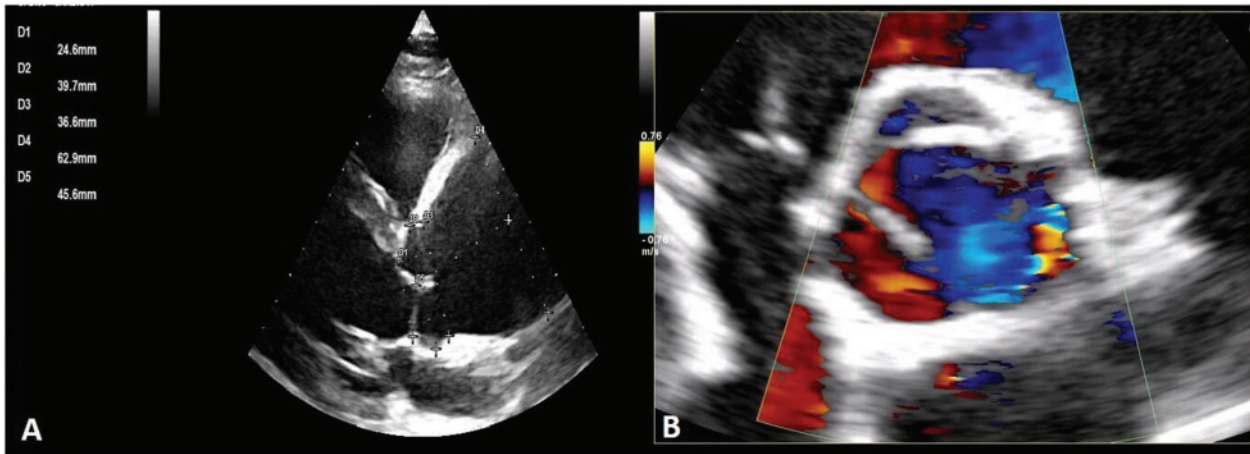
Transthoracic echocardiography. (A) Parasternal long-axis view showing aortic root dilatation (39.7 mm) and proximal ascending aortic aneurysm (36 mm). (B) Tricuspid aortic valve in parasternal short-axis view with colour Doppler.
